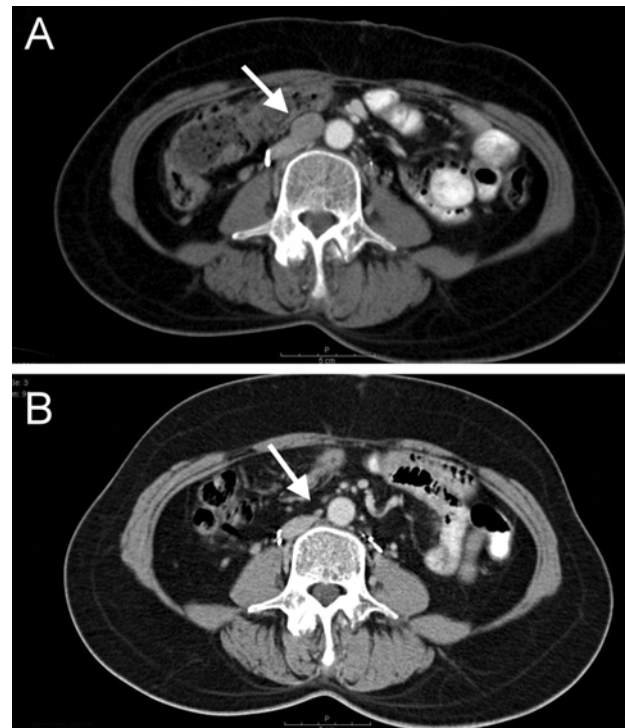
(a) Enlarged right paraaortic lymph node (arrow) was detected by CT at the first relapse (September, 2004). (b) Follow-up CT after treatment (December, 2005) shows complete remission at the PA region (arrow), and serial follow-up scans on August, 2007, March, 2008, and April, 2011 show that the patient remains in remission.
